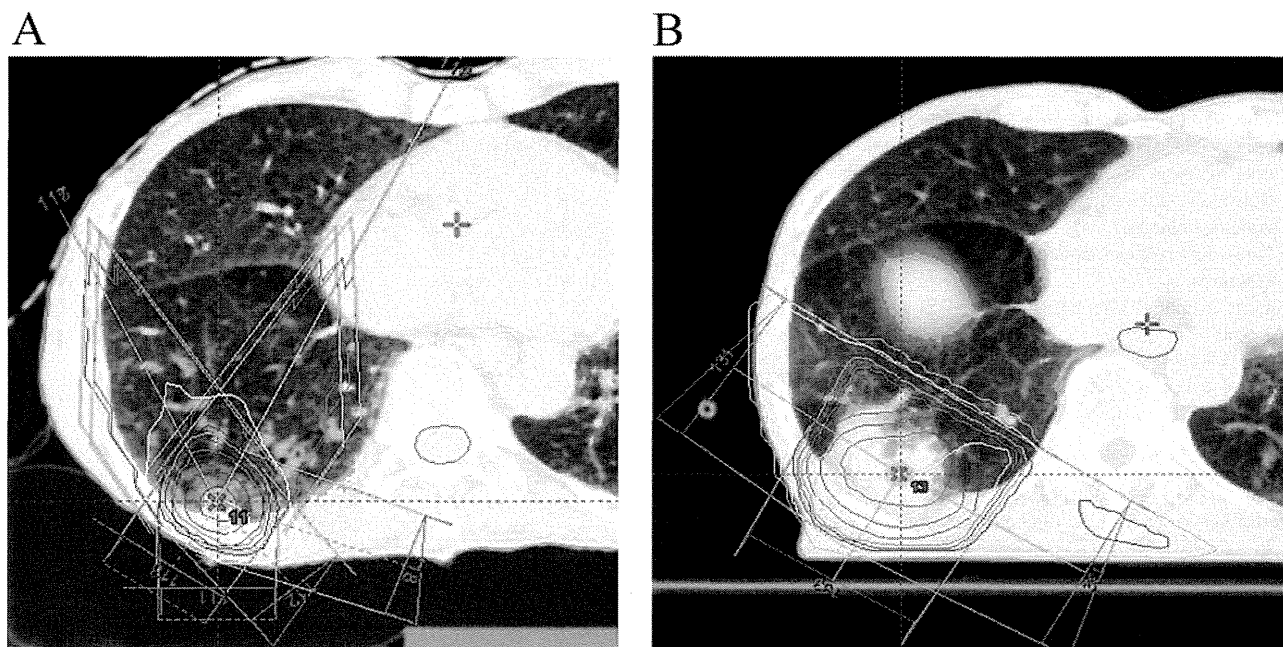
A computed tomographic (CT) image of a 79-year-old male with cT1aN0M0 squamous cell lung carcinoma of the lower right lobe. A: stereotactic body radiotherapy (SBRT) was performed for primary lung cancer with a dose of 48 Gy in four fractions. B: Re-irradiation with doses of 60 Gy in 30 fractions was performed for local recurrence which was confirmed by CT-guided biopsy 14 months after SBRT. The patient died of another disease one year after re-irradiation, without disease progression.
